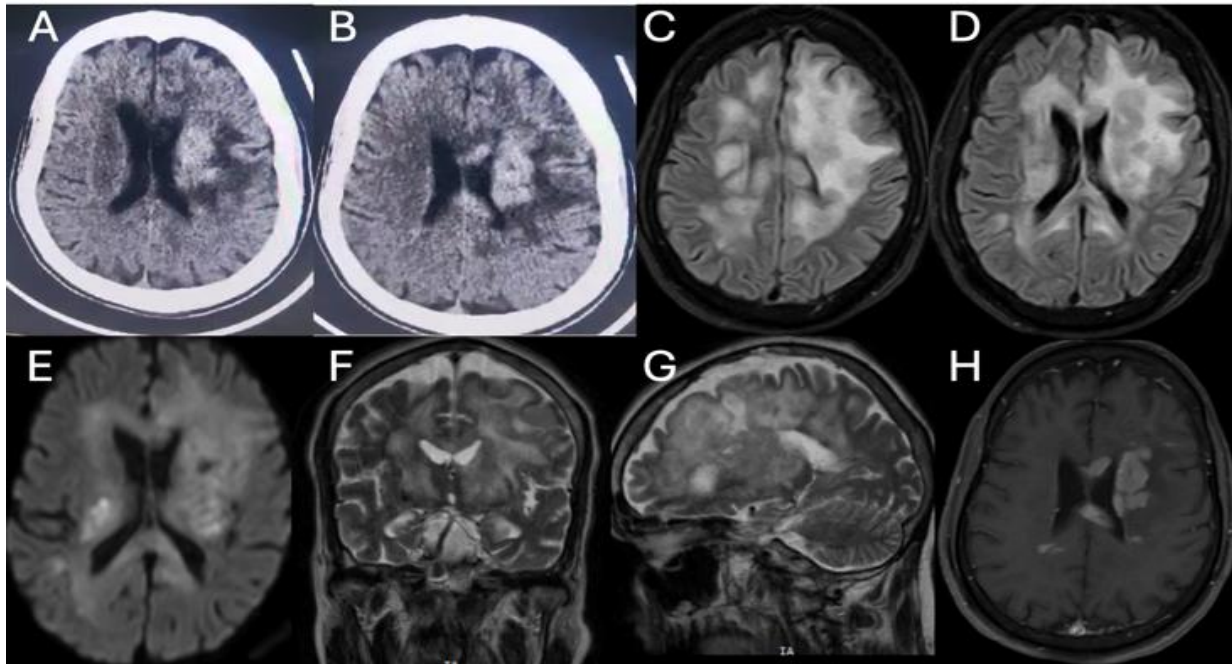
Brain imaging (second presentation) – A, B- Plain CT brain showing periventricular white matter hyperdensity involving corpus callosum (genu and splenium) with surrounding hypodense edema. C, D – FLAIR imaging showing hyperintensities in the frontoparietal periventricular>subcortical white matter including splenium and genu of corpus callosum with areas of hypointensities within. Note that the lesions have increased compared to initial imaging. E- diffusion restriction of the lesions. H) intense contrast enhancement of the same
